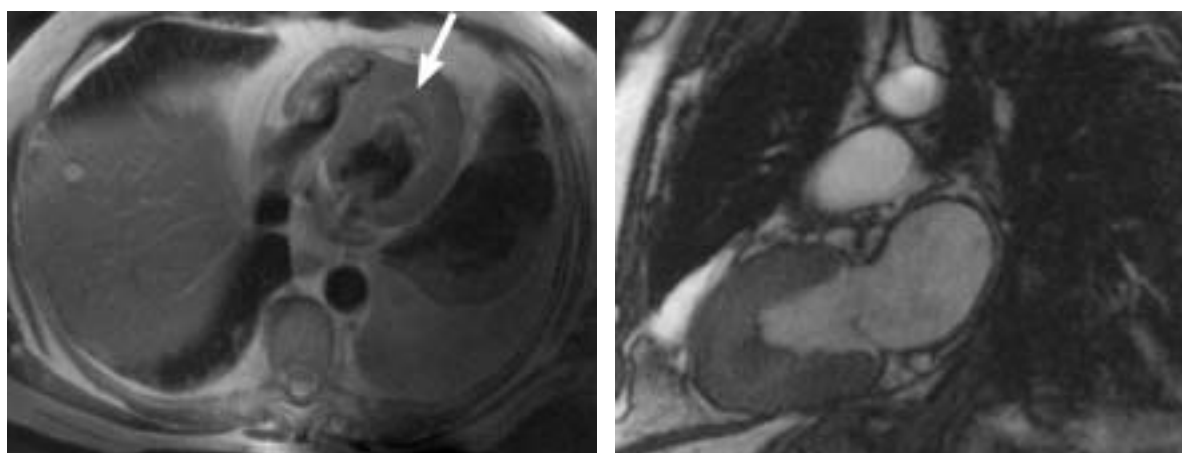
Magnetic resonance images of the heart. Left, Spin-echo (black-blood) sequence reveals a slow flow-related signal artifact and a suspected mass (arrow) in the left ventricular apex. Right, On cine (white-blood) sequence, the suspected mass appears to be only a thickening of the akinetic apical myocardium.
